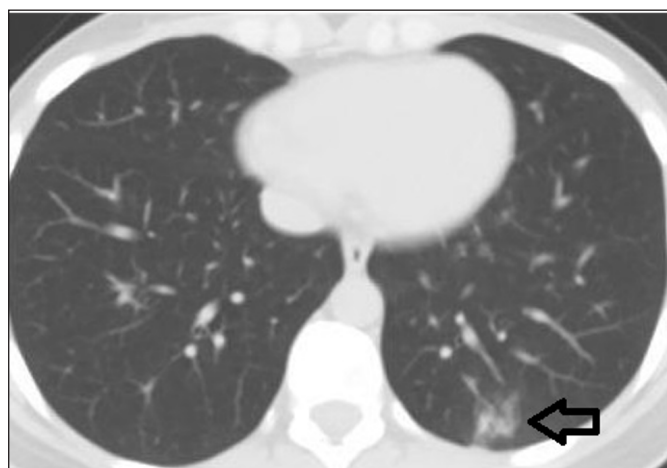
a. Axial unenhanced chest CT image of 35 year old patient with Wuhan Type COVID-19 pneumonia shows peripheral GGOs b. Axial unenhanced chest CT image of patient with infected with B.1.1.7 variant shows nodular and patchy GGOs in central peribroncovascular area.
